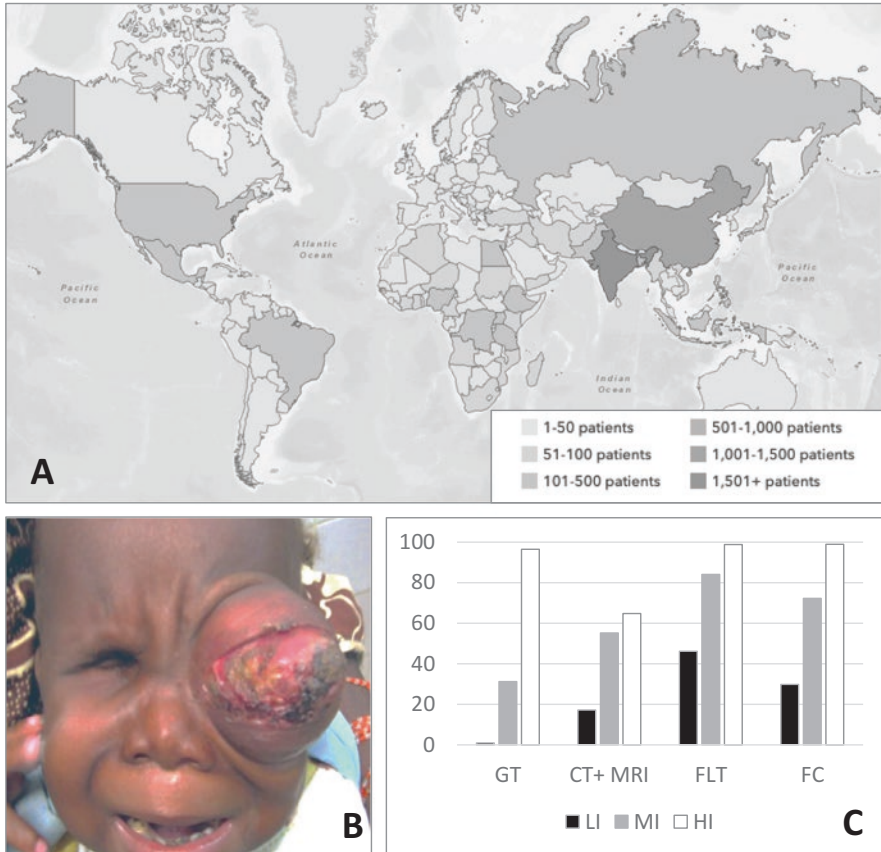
Worldwide distribution of retinoblastoma. (a) Estimates of geographic distribution of retinoblastoma cases (number of cases), from [38]. (b) Presentation of retinoblastoma in a 3-year-old girl, Bamako, Mali. (From [40], reproduced with permission). (c) Availability of resources for RB diagnosis and treatment in low (LI)-, middle (MI)-, and high (HI)-income countries, as percentage of centers with access with these resources. *GT* genetic testing; *CT + MRI* computerized tomography+magnetic resonance imaging; *FLT* focal laser therapy; *FC* focal (intravitreal) chemotherapy
